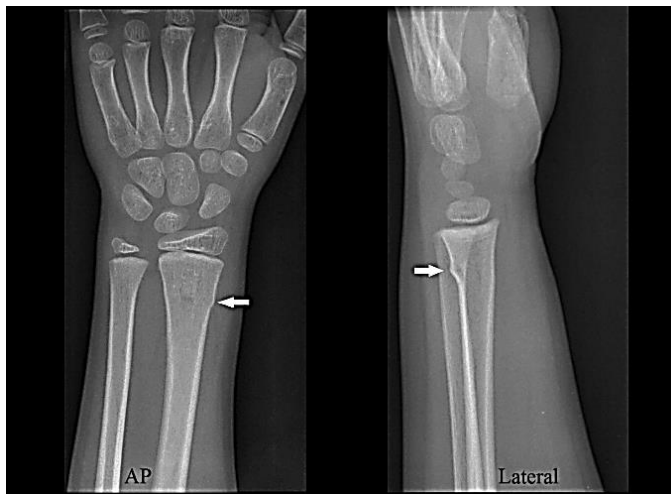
X-ray image of a buckle fracture
